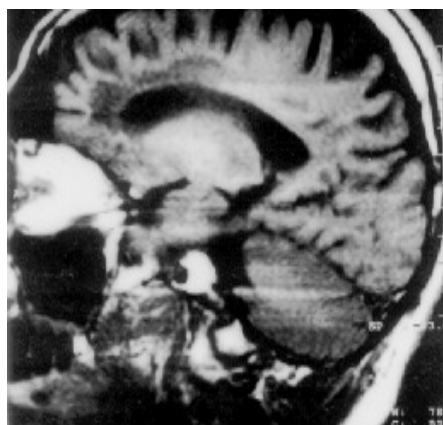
Case No2. A T1-dependent MRI-CT image of the vertical cross-section of the brain. Around the frontal horn of the lateral ventricle, an irregular hypodense zone indicative of demyelination may be seen.
